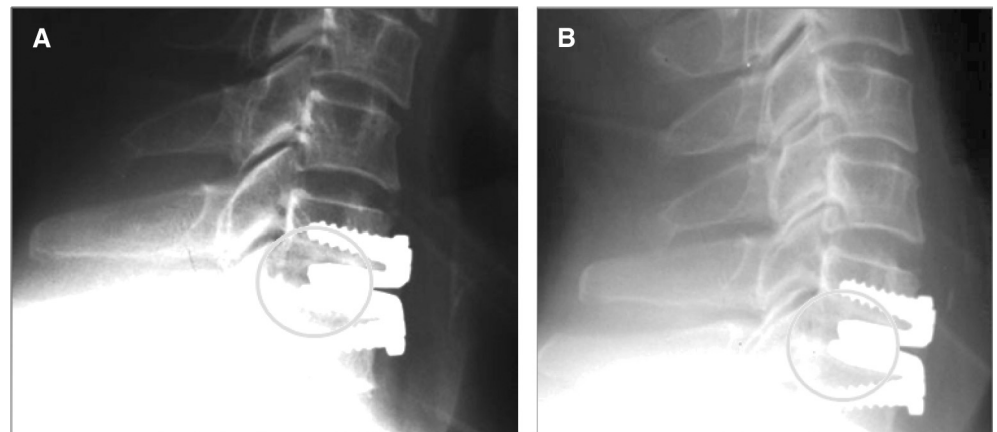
Lateral flexion (A) and extension (B) x-rays demonstrating restricted cervical range of motion in a patient in which the implant did not cover the posterior endplate.
